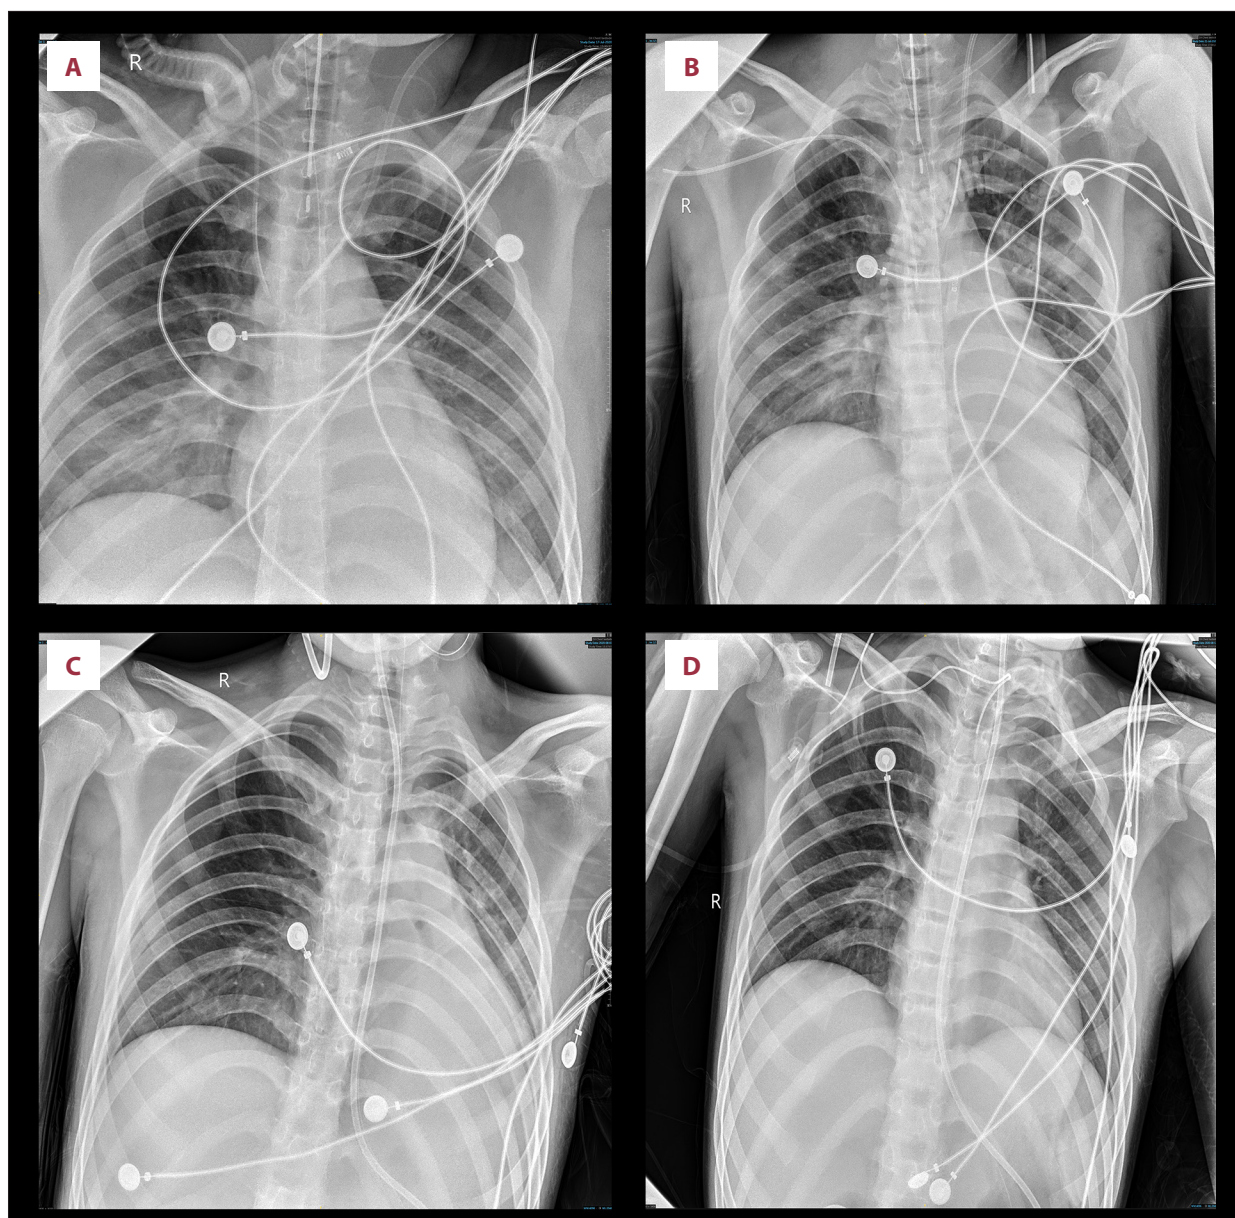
Chest X-ray findings of the patient. Chest radiographs obtained at different time points during hospitalization. On hospital day 3 (A), slightly increased and thickened pulmonary markings with patchy opacities and blurred margins were observed in both lower lung fields. On hospital day 7 (B), a patchy area of increased density with blurred margins was observed in the middle field of the left lung. On hospital day 24 (C), compared with previous findings, patchy opacities in the middle and lower lung fields were partially absorbed. A patchy area of increased density with relatively clear margins was observed in the upper field of the right lung, with local pleural adhesion at the right lung apex. On hospital day 34 (D), pulmonary markings were distinct, with no obvious abnormalities detected.
